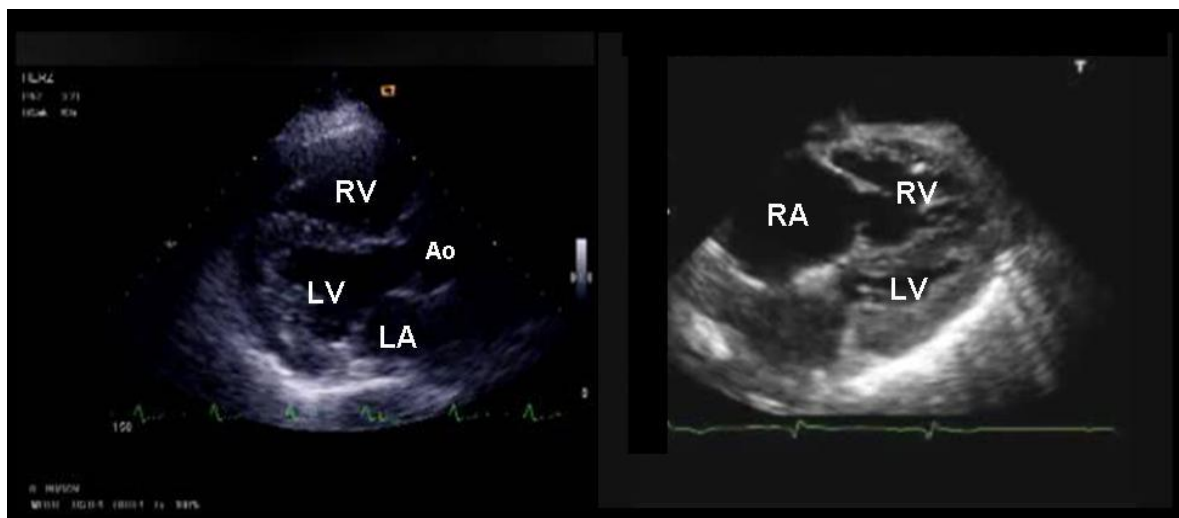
Right heart dilatation in the presence of massive pulmonary embolism in a critically ill patient. To the left is a parasternal long axis view, showing the RV to be dilated (eyeballing, it can be compared with the size of the ascending aorta or left atrium in this view). To the right is a subcostal four-chamber view. The right heart is dilated, and the left ventricle appears small and squashed.
